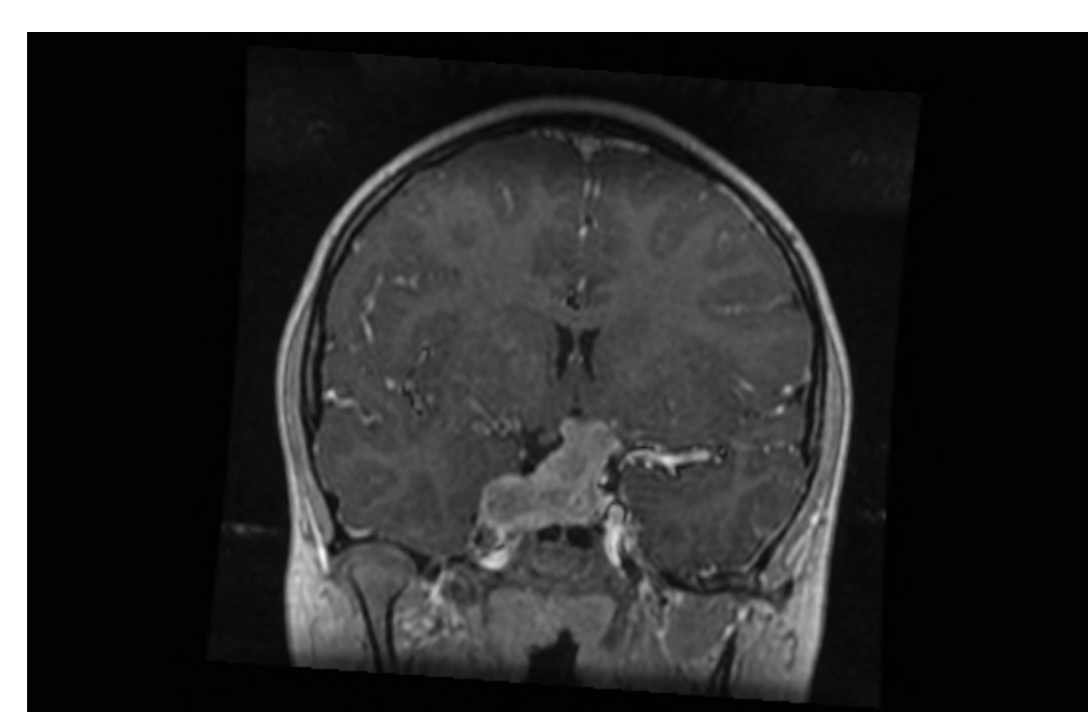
1 MRI, T1, before surgery
